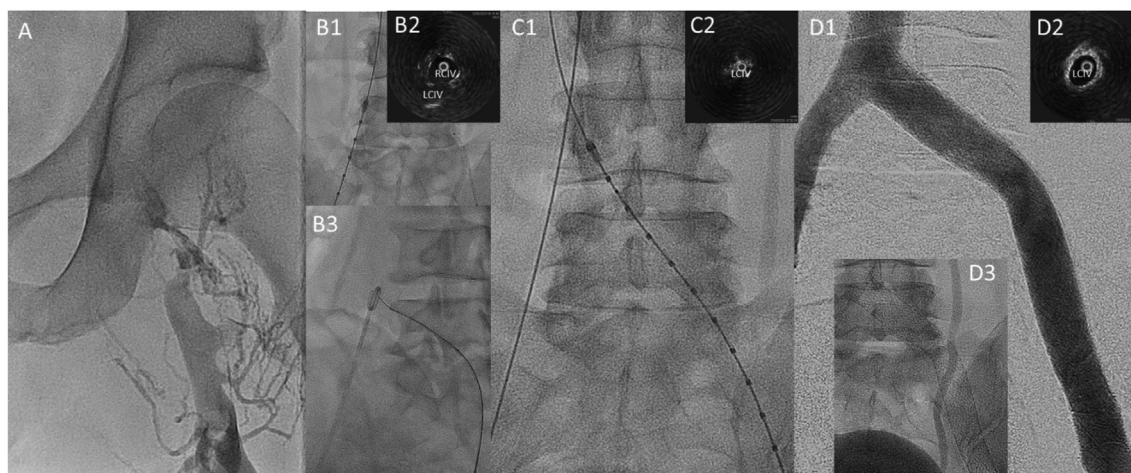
Case example of Endovenous stenting for chronic LCIV occlusion. A: baseline venography showing occlusion of common femoral vein. B1: IVUS interrogation from contralateral RCIV to mark the position of LCIV (B2); B3: pigtail from contralateral RCIV positioned at level marked by IVUS for puncturing. C1: IVUS from ipsilateral LCIV for confirming true lumen and for confirming compression aetiology (C2). D1: Final venography after stent (D3) implantation with IVUS showing good stent expansion against compression. IVUS = intravascular ultrasound, LCIV = left common iliac vein, RCIV = right common iliac vein.
